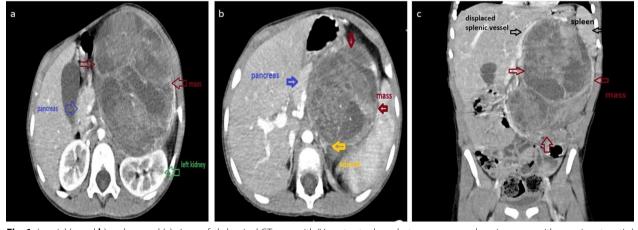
In axial (a and b) and coronal (c) views of abdominal CT scan with IV contrast, a large heterogeneous enhancing mass with prominent cystic/ necrotic components is identified in the left upper quadrant. The mass is distinct from surrounding structures, including the pancreas, left kidney, left adrenal gland, and spleen. It causes anterior displacement of the stomach and the body and tail of the pancreas. No evidence of direct invasion into adjacent organs is noted
